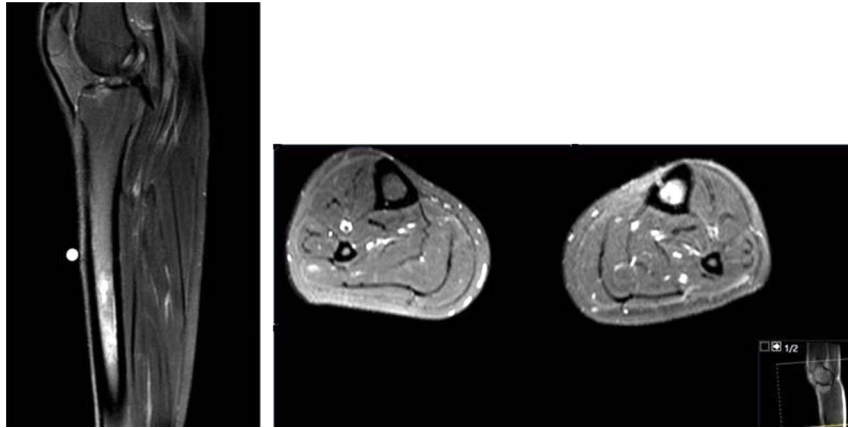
T2-weighted MRI of the left tibia showing bone and marrow edema, microabscess, and a fistula.
